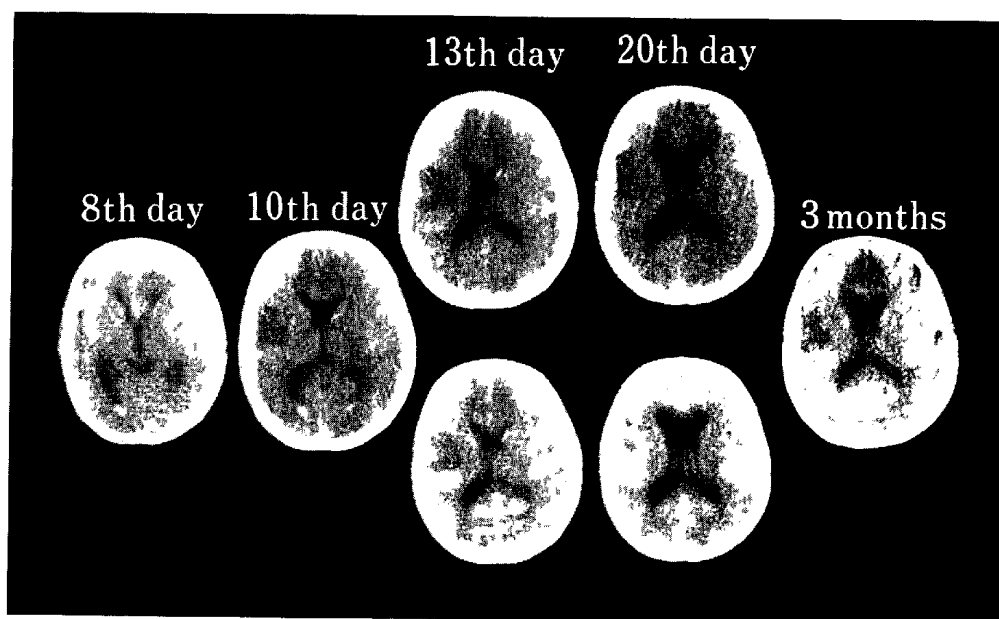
Repeated CT scans of Case 1. Low density areas can be seen in the territory of ACA and MCA on the 10th day after the attack. They are more clearly defined on the 13th day and slightly enhanced (lower). Marked enhancement is seen on the 20th day (lower). After 3 months, sharp margined low density areas are observed corresponding to the enhanced areas.
